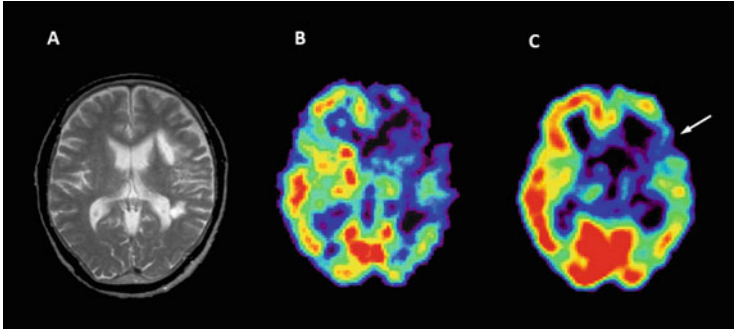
Selective neuronal loss: (a) T₂-weighted image (T₂WI) in a patient with subcortical infarction of the left putamen 1.5 months after onset, (b) CBF image of the corresponding slice obtained by ¹²³I-IMP SPECT, and (c) ¹²³I-iomazenil SPECT image of the corresponding slice. The MR image showed no obvious lesion in the left cortical area, whereas ¹²³I-iomazenil SPECT demonstrated a decrease in accumulation (*white arrow*), indicating selective neuronal loss. The CBF reduction extended beyond the cortical areas of ¹²³I-iomazenil reduction (Reprinted from *Brain Mapping: An Encyclopedic Reference*, Vol. 3/1st edition, Arthur W. Toga (Editor in Chief), Hemodynamic and Metabolic Disturbances in Acute Cerebral Infarction (title)/Clinical Brain Mapping (chapter), written by E. Shimosegawa, p. 829–838, 2015, with permission from Elsevier)
